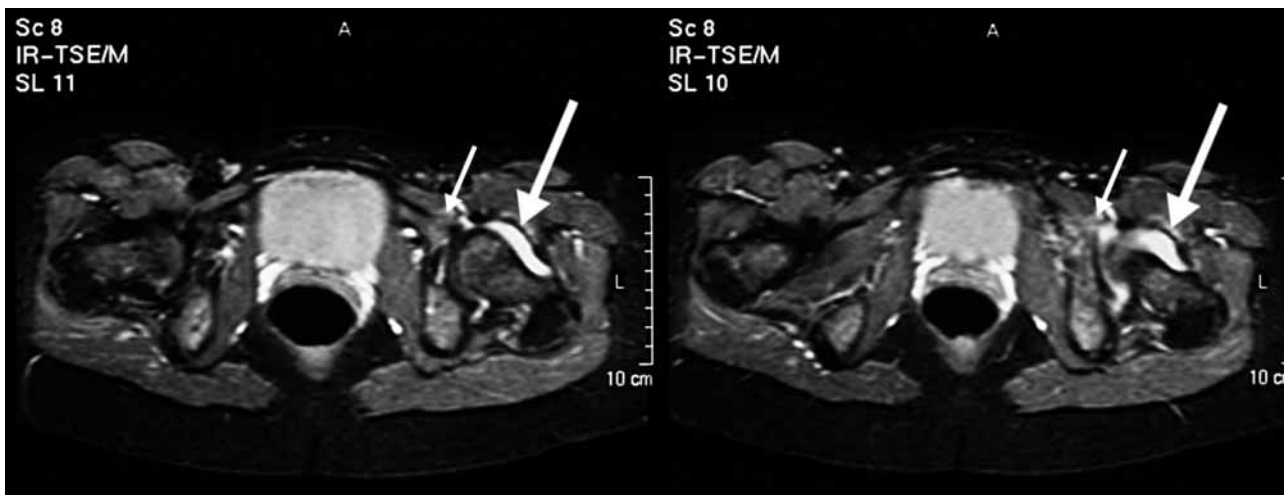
Frontal view of the left hip showing an increased signal on T2-weighted images involving the iliopsoas muscle, and fluid collection in the hip joint.
